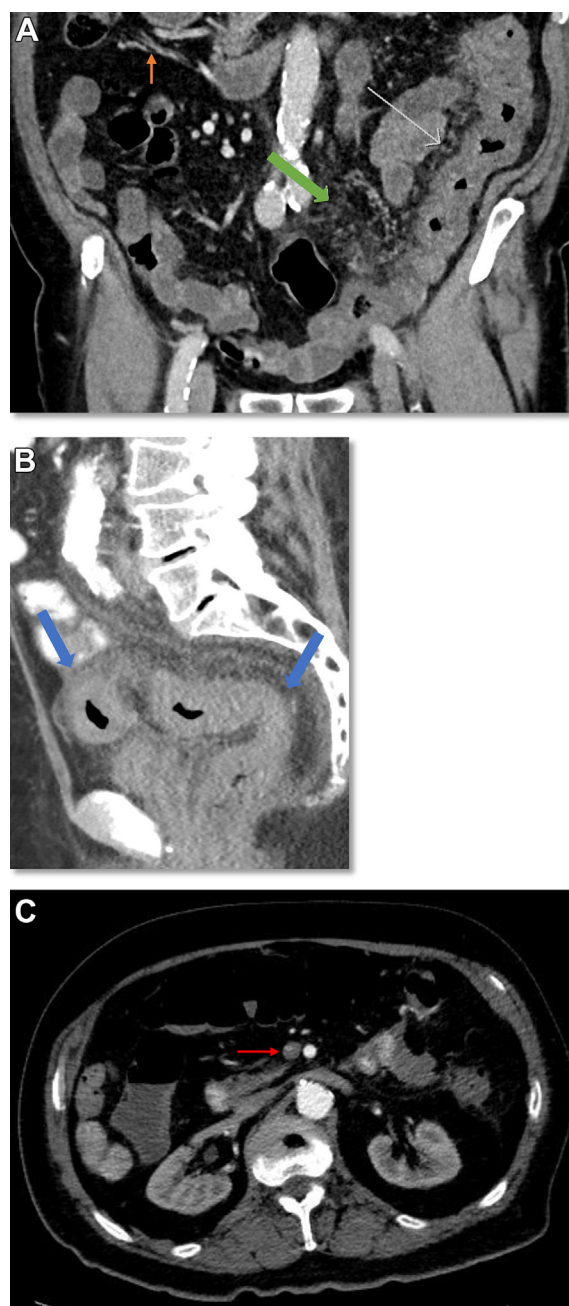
Computed tomography (CT) angiograms of the abdomen and pelvis demonstrating acute on chronic inflammatory changes of the descending colon. A, The wall of the descending colon was moderately thickened with pericolonic soft tissue attenuation stranding, consistent with active inflammation (white arrow). Arterial branches of the inferior mesenteric artery at the left lower quadrant had an abnormal serpiginous morphology and tortuosity (green arrow), in contrast to normal linear morphology arteries at the right mid-abdomen (orange arrow), consistent with a chronic process. B, Inflammation involving the rectosigmoid colon (blue arrows). C, Inferior mesenteric vein wall thickening vs thrombus with contrast filling a narrowed lumen (red arrow).
